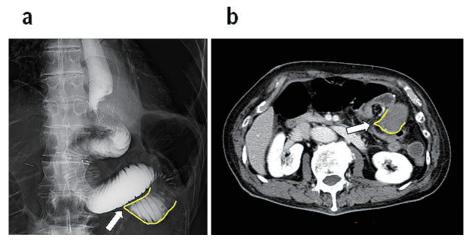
Radiological findings of case 2. (a) Fluoroscope imaging; white arrow shows obstruction point and beak sign (yellow color's line). (b) CT imaging; white arrow shows obstruction point and beak sign (yellow color's line).
